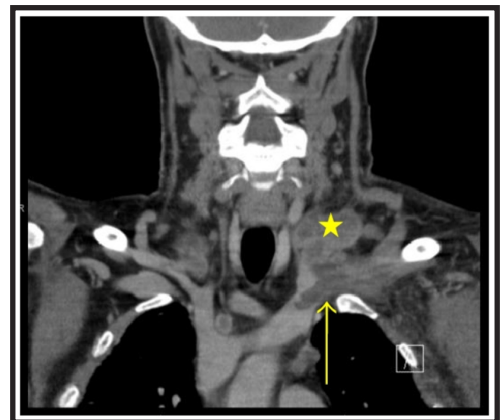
CT angiography showing thrombus in the left subclavian vein
